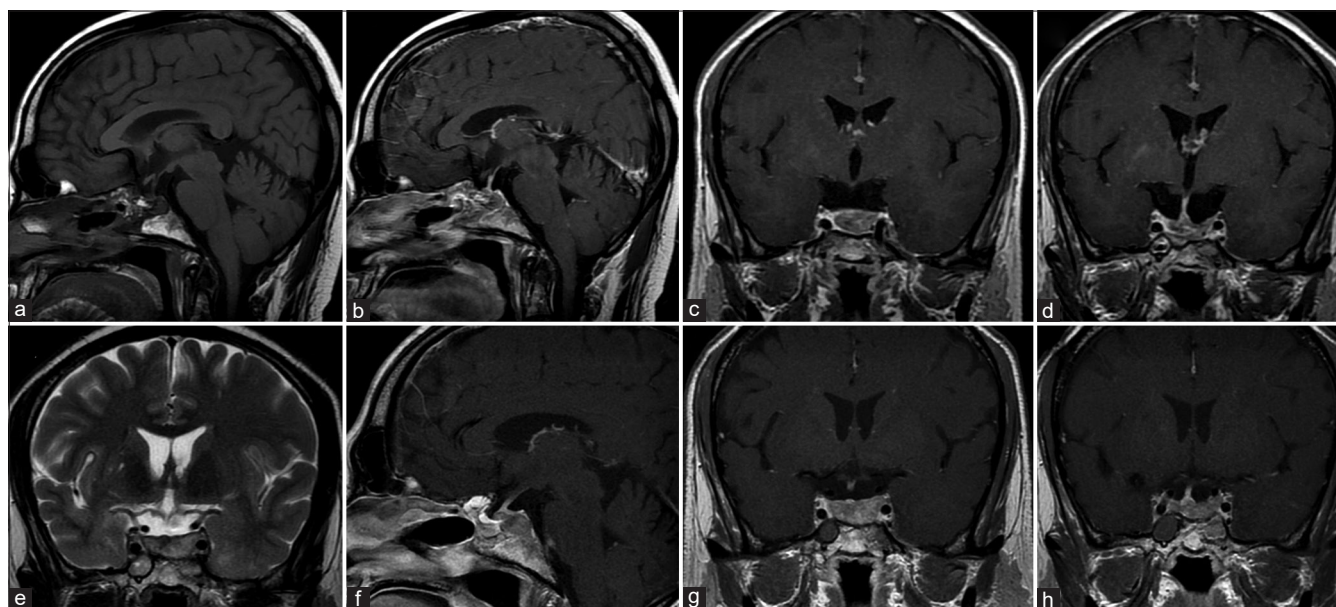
Magnetic resonance imaging (MRI) images of the sella 3 months after the first endoscopic endonasal excision of a large pituitary macroadenoma demonstrating residual tumor (a-d). Residual tumor enlargement is noted in the follow-up MRI done 3 years later (e-h).
